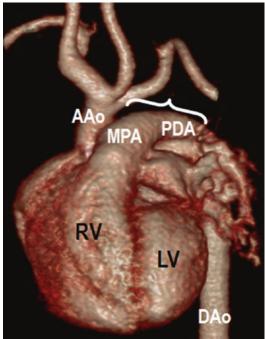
The findings of a type A interruption are easily seen on a 3D surface rendered CTA image. The ascending aorta (AAo) is normal caliber and the three brachiocephalic arteries branch from the proximal aortic arch. The aortic arch is interrupted distal to the left subclavian artery (*bracket*). The main pulmonary artery (MPA) exits the right ventricle (RV) and continues as the patent ductus arteriosus (PDA) to supply blood flow to the descending aorta (DAo)
